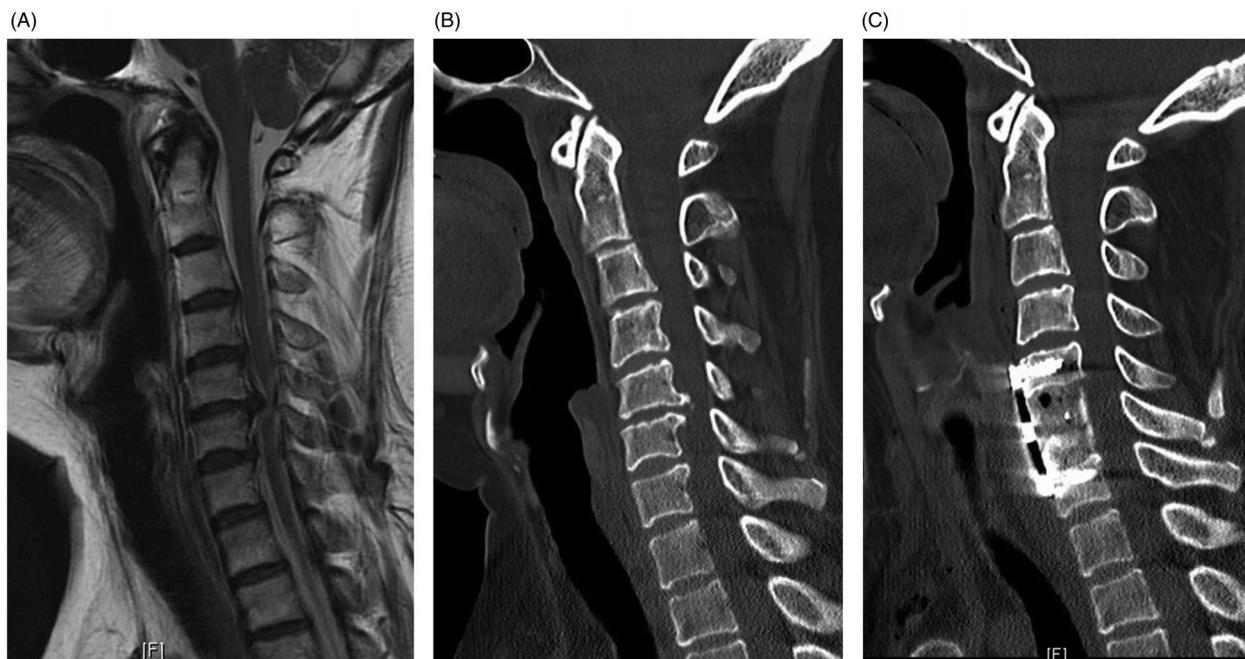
Preoperative T2 sagittal magnetic resonance imaging (A) and plain computed tomography (B) of the cervical spine of a 50-year-old lady showing C5/6 cervical stenosis with a prolapsed disc and posterior osteophytes. She had hoarseness of voice after the operation and postoperative day 1 radiograph (C) had shown significant pre-vertebral swelling. Her symptoms subsequently resolved and did not require reintubation. Her length of stay in the ICU was one day and was discharged to the general ward the next day.
